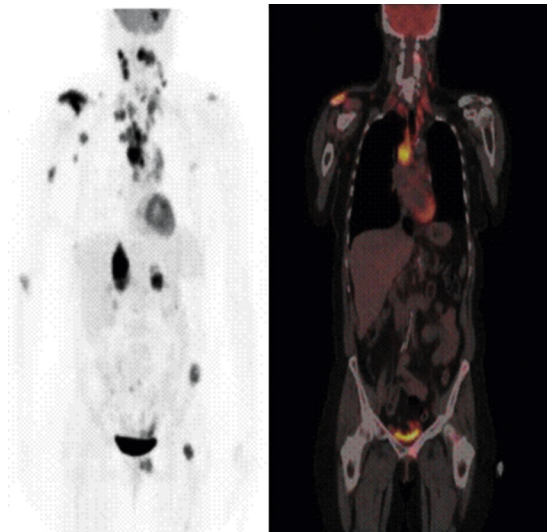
Intense Glucose Requirement Aids in Diagnosis of Metastatic Non–Small Cell Lung Cancer. This 54-year-old woman had a non–small cell lung cancer (NSCLC) resected from the left upper lobe. Five years later, these studies were obtained. The positron emission tomography (PET) scan using 18-fluorodeoxyglucose (FDG) shows metastatic lesions in the brain, right shoulder, and mediastinal and cervical lymph nodes, as well as in the liver, left pelvis, and proximal femur. PET whole-body image (left): Representative coronal image from the whole-body FDG-PET/CT–fused image of the same patient (right). The fused image consists of the computed tomography (CT) image with the metabolic information superimposed in color. The pattern of spread is most likely from the primary tumor to the large mediastinal lymph nodes, followed by lymphatic spread to cervical nodes. Blood-borne dissemination produced the bone, brain, and liver metastases. Normally, only the heart, brain, and bladder show a strong signal in PET scans. (Images courtesy John Hoffman, MD, Huntsman Cancer Institute, Salt Lake City, UT.)
